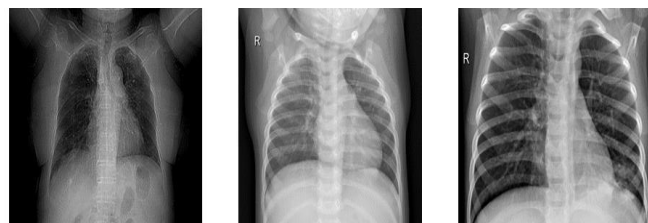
Example chest radiography images
